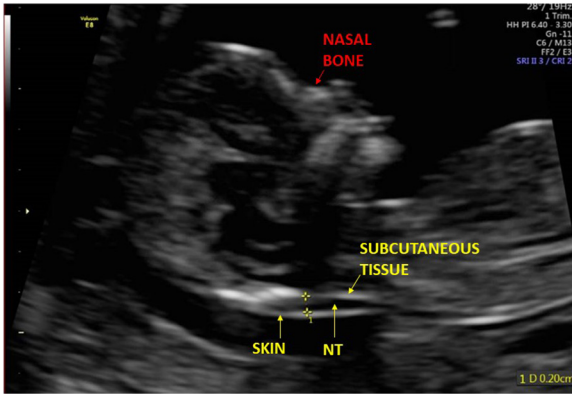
Transabdominal ultrasound image of a nuchal translucency (NT) measurement. The calipers are placed perpendicularly between the skin and the subcutaneous tissue, with the fetus in a neutral position. The amnion is clearly seen below the skin. Nasal bone is also present in this image.
